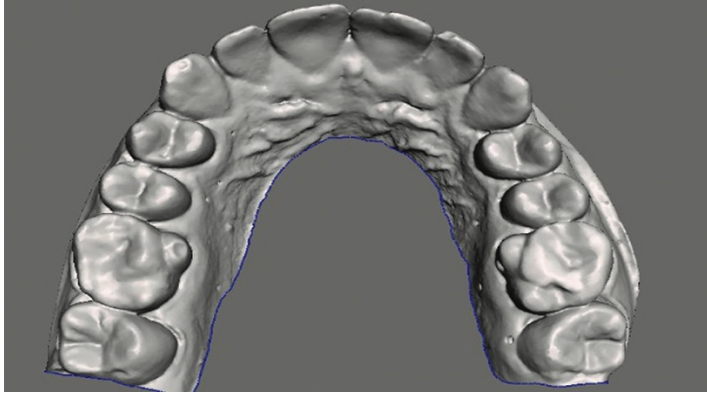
Digital model obtained from CBCT scan of the stone cast
